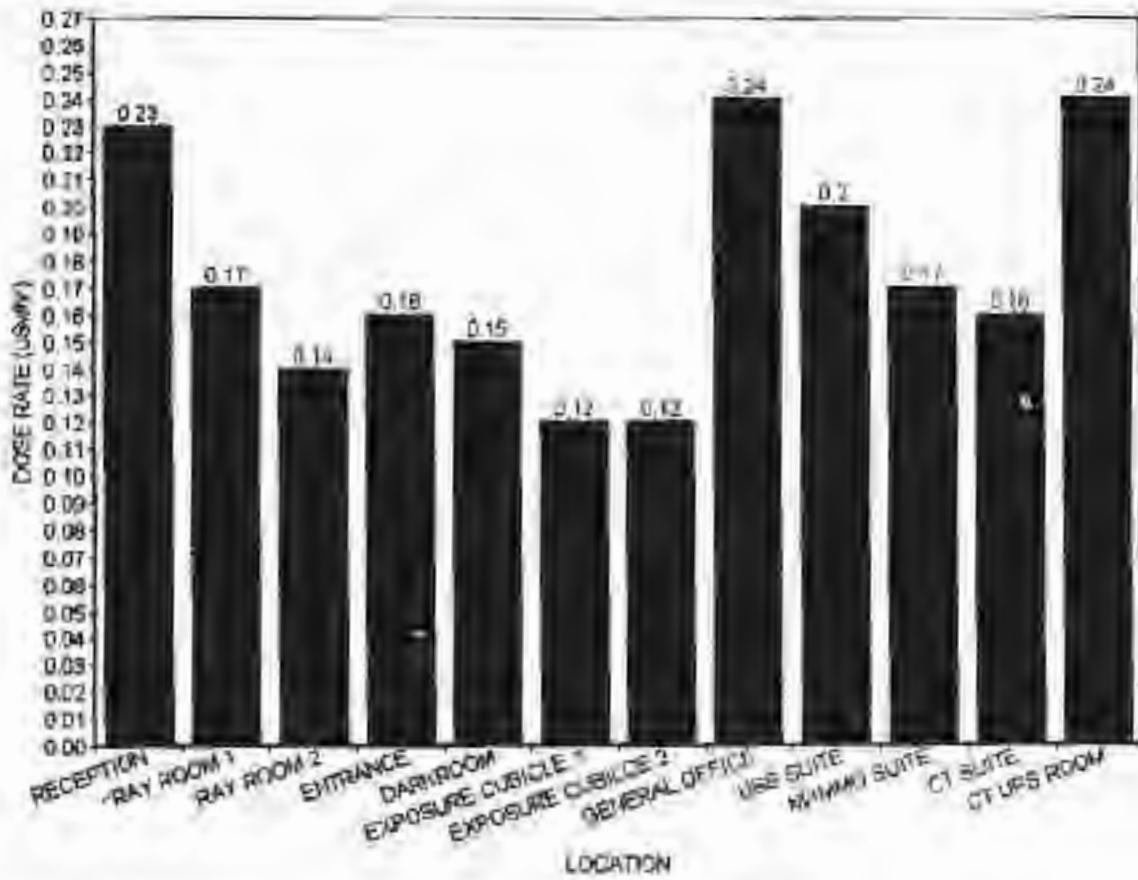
Dose rates values compared to standard for X-ray department
